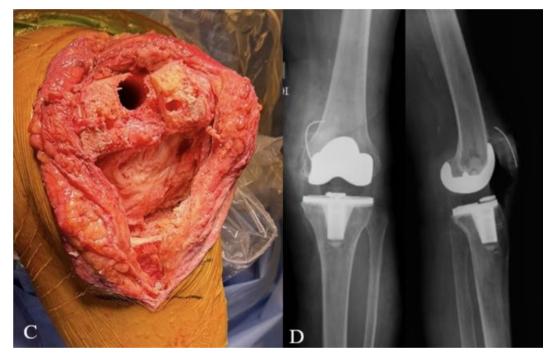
Intraoperative image and postoperative radiographs, C: Intraoperative image of the knee. D: Immediate postoperative anteroposterior knee radiograph and lateral knee radiograph showing a well-positioned prosthesis with no intraoperative fractures, as well as removal of most of the previous metallic wires.
